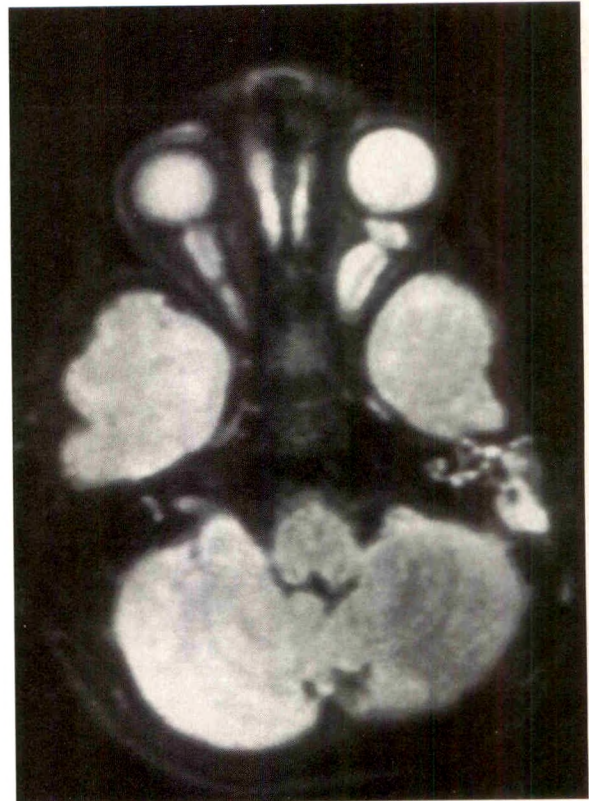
(Imes and Hoyt). Case 4. T₂-weighted axial magnetic resonance image. A zone of high signal intensity surrounds a core of lower signal intensity in each tubularly thickened optic nerve.
